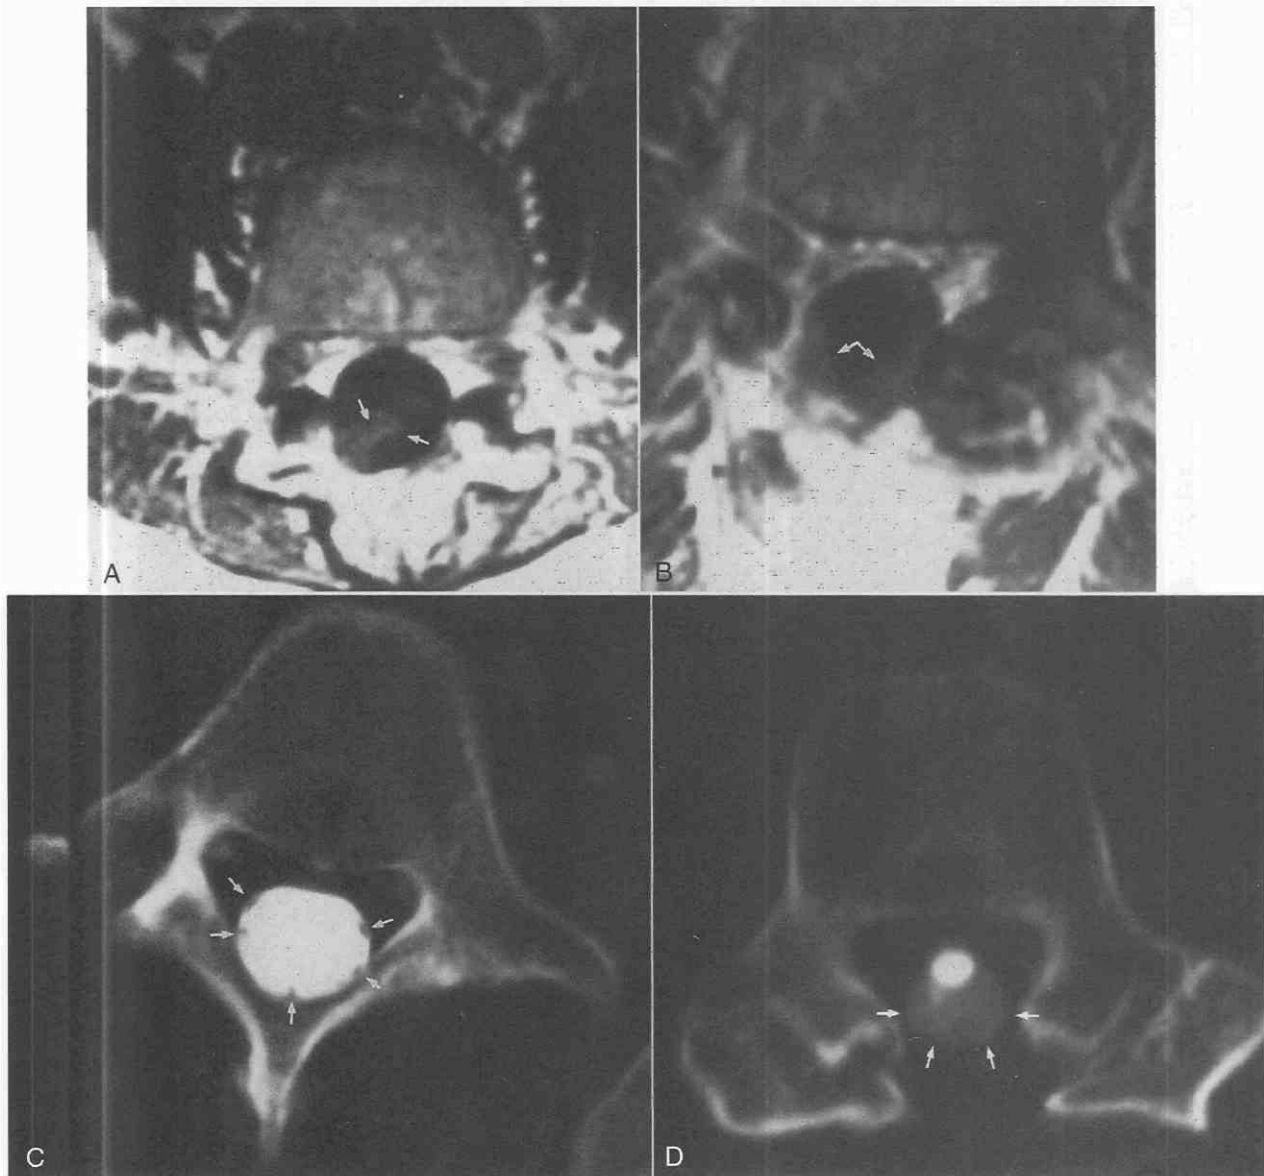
Arachnoiditis. *A*, Axial postoperative unenhanced T1-weighted MR image shows clumping of nerve roots (*arrows*) within the spinal canal. *B*, Enhanced scan in another postoperative patient shows the nerve roots adhering peripherally to the dura (*arrows*). Note that root enhancement is not a feature. *C*, Postmyelogram CT scan shows nerve roots adhering peripherally to the dura (*arrows*). This gives the appearance of an “empty” thecal sac. *D*, Postmyelogram CT scan shows advanced arachnoiditis. Most of the spinal canal is filled with inflammatory tissue (*arrows*), with only a small amount of contrast noted anteriorly.
